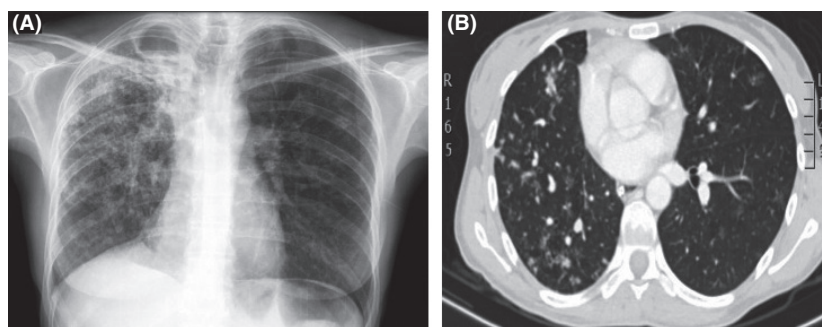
(A) The AP chest X-ray showed a loss of volume in the right lung with ipsilateral mediastinal shift and bilateral interstitial and alveolar infiltrates that were distributed predominantly in the right lung parenchyma with cavitations in the right upper lobe. (B) The CT showed a loss of volume in the right lung and bilateral pseudonodular infiltrates predominantly localized in the right lung.
